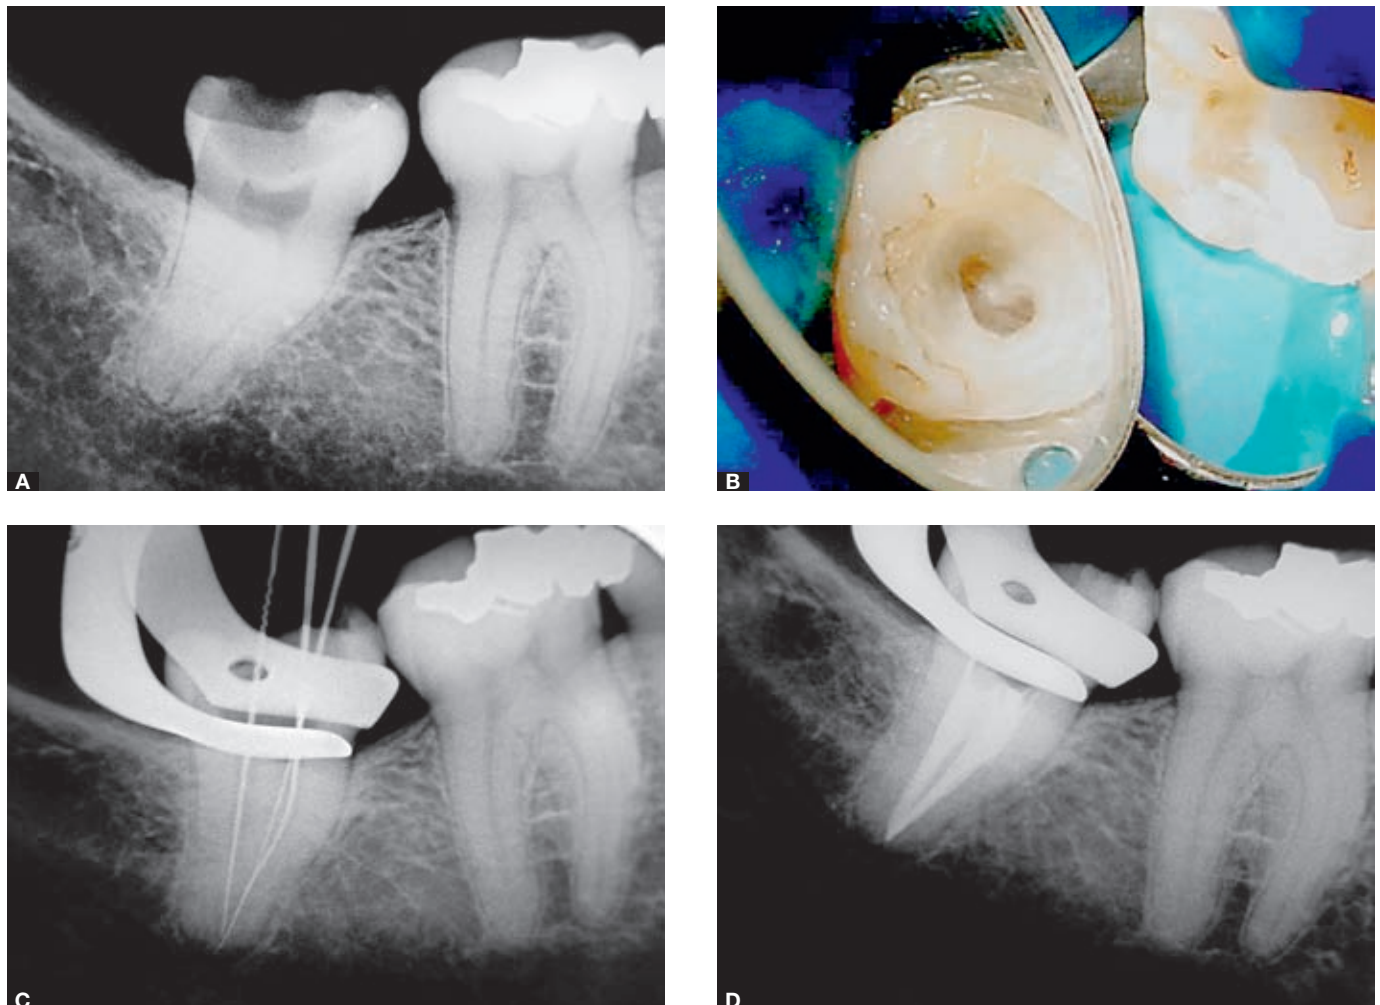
A) Preoperative radiograph. B) Image showing the C-Shaped canal. C) Working length radiograph. D) Final radiograph.
